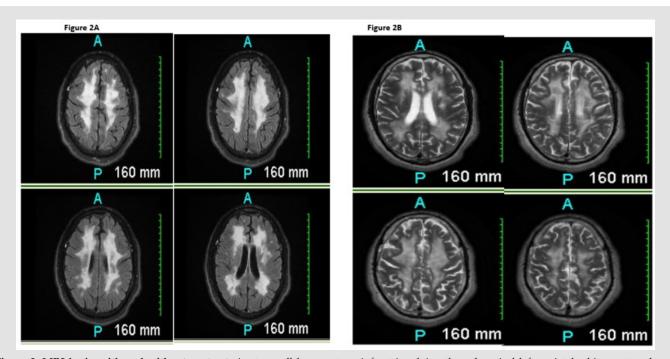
MRI brain with and without contrast: Acute small lacunar type infarct involving the subcortical left parietal white matter above. detailed above Extensive multifocal confluent areas of abvenormal signal involving the supratentorial white matter as detailed above otherwise minimally changed from previous exam. Hypercoagulable states including CADASIL May BE considered given this distribution.
